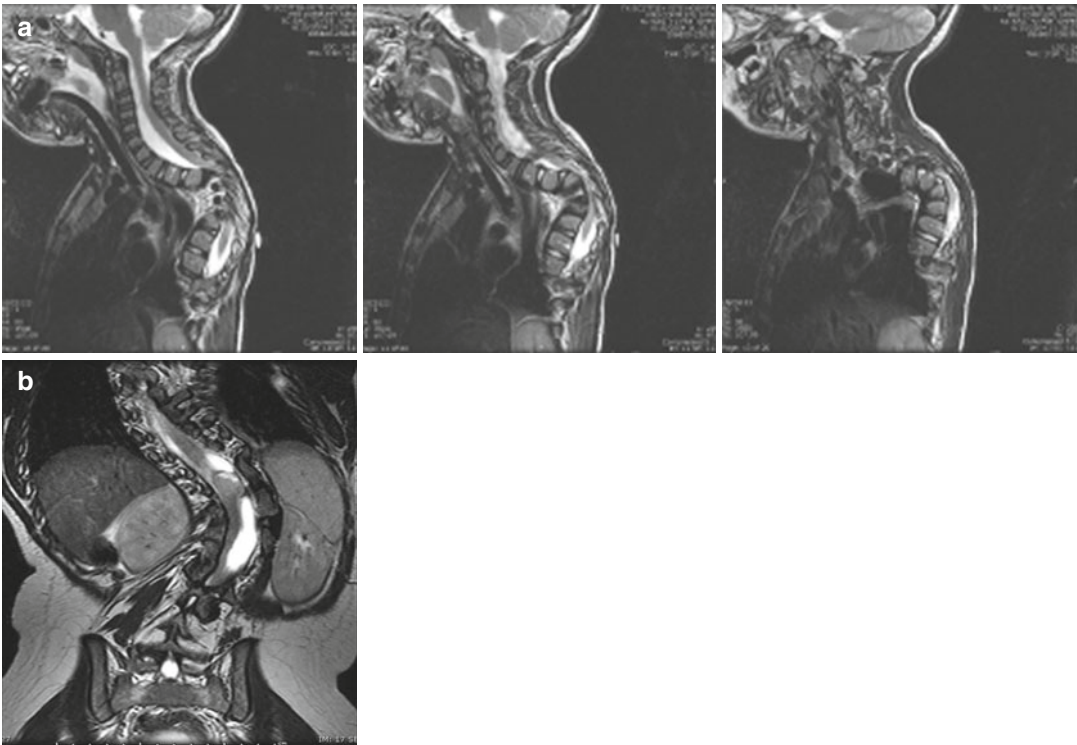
(a) Cord compression with paraparesis in a 6-year-old patient with Pierre-Robin syndrome. Surgical decompression, not HGT, is indicated; (b) MRI revealing cystic
